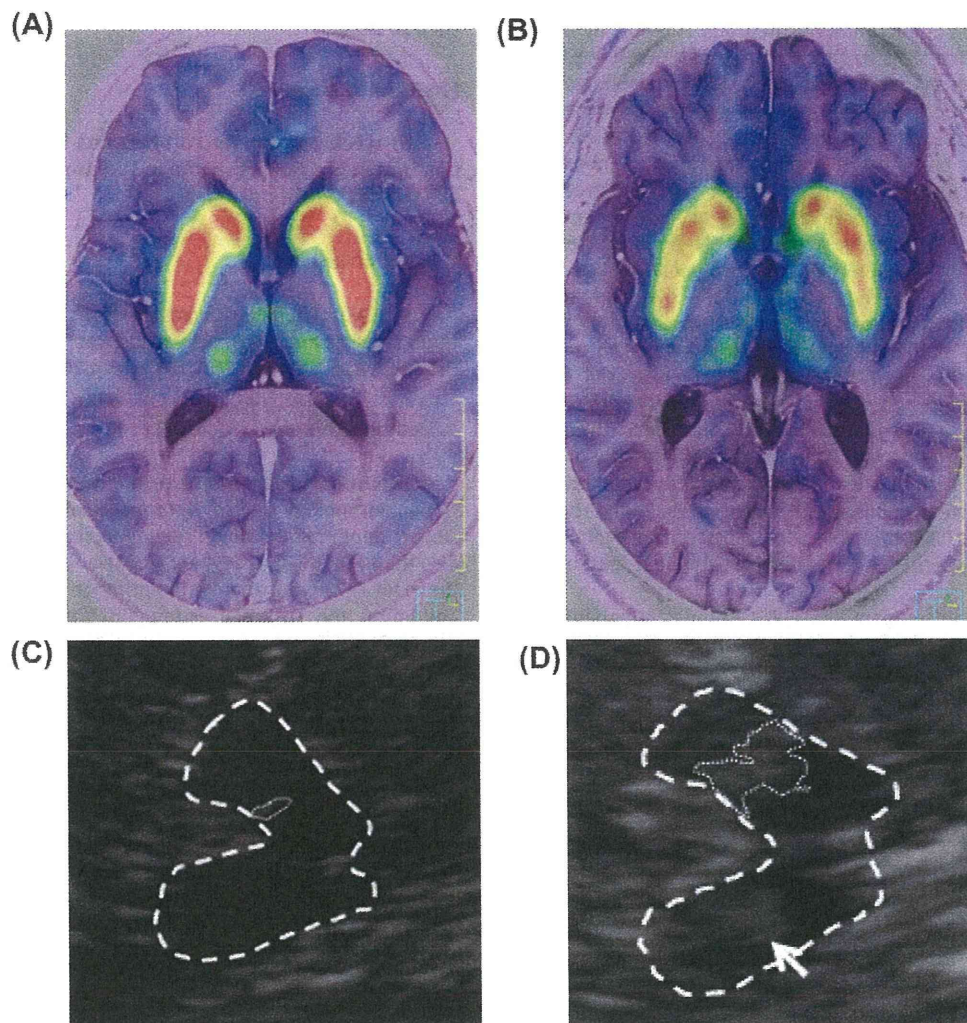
(A) $6\text{-}^{[18}\text{F}]$ Fluoro-meta-tyrosine positron emission tomography ($6\text{-}^{[18}\text{F}]$ FMT PET) on magnetic resonance imaging (MRI). This demonstrates preserved dopamine terminals in the caudate and putamen in a healthy subject. (B) $6\text{-}^{[18}\text{F}]$ FMT PET on MRI. This demonstrates patchy decreased dopamine terminals in the caudate and putamen in a patient with idiopathic rapid eye movement sleep behaviour disorder (iRBD). (C) Transcranial sonography (TCS) of bilateral substantia nigra (SN) hyperechogenicity in a healthy subject. The area of hyperechogenic SN signal within the hypo-echogenic crus cerebri is encircled on the ipsilateral side for planimetric measurement (0.10 cm^2). (D) TCS of bilateral SN hyperechogenicity in a patient with iRBD. The area of the hyperechogenic SN signal within the hypo-echogenic crus cerebri is encircled on the ipsilateral side for planimetric measurement (0.44 cm^2).
